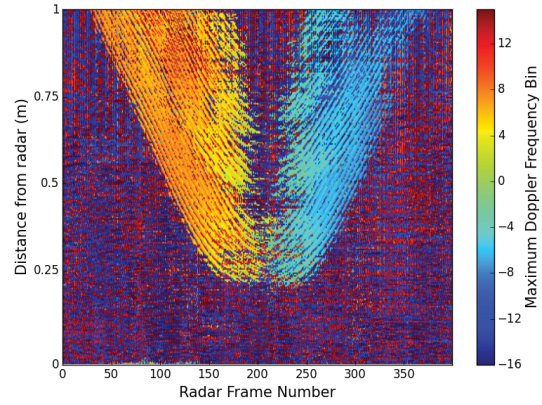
[Figure Best Viewed in Color] Doppler during a doorway crossing: A person causes a positive Doppler shift while walking towards the doorway, and a negative Doppler shift while walking away.
